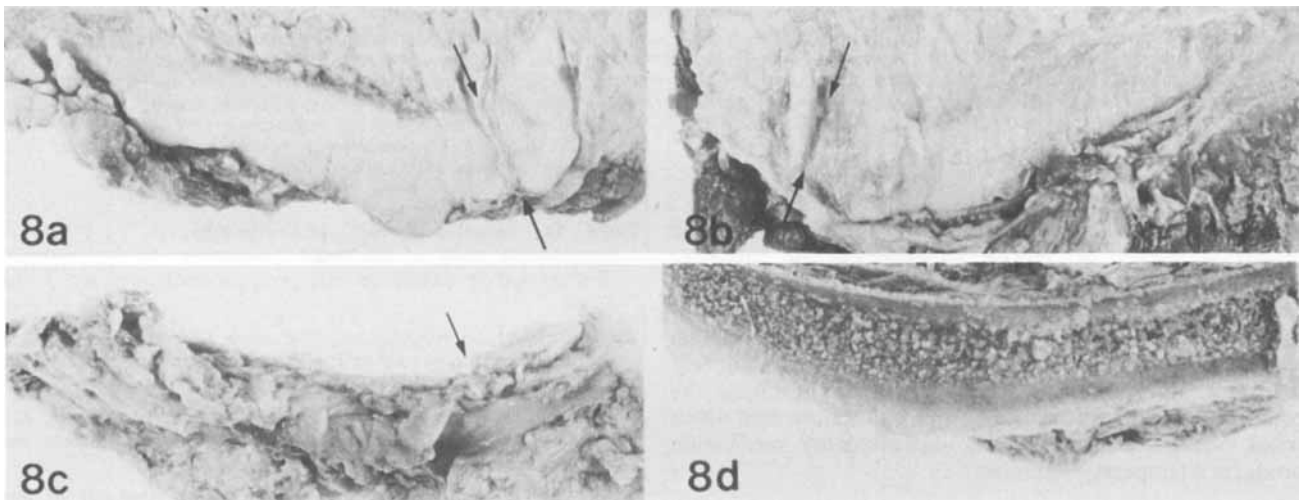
(a) Large dorsal eminence covered by articular cartilage, Type 3, on the most medial aspect (arrows) of the left sacral joint surface of a five-year-old Holstein gelding (Case 5). (b) A depression on the iliac surface (arrows) corresponding to the dorsal eminence in Fig 8a. (c) Caudocranial view of the same area as in Fig 8a showing the concavity of the sacral surface caused by the dorsal eminence on the medial aspect of the sacral wing (arrow). A radiograph of a slab from this area is shown in Fig 5b. (d) Caudocranial view of a section through the same area as in Fig 8b showing the convex iliac surface
